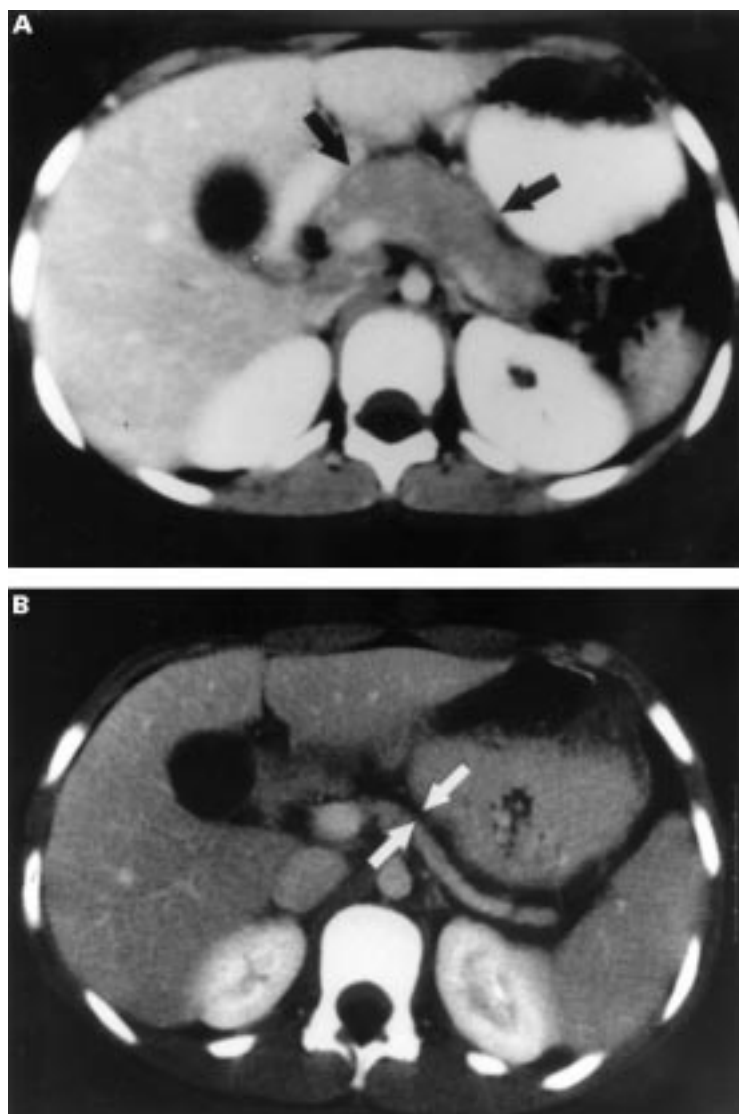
Abdominal CT scan of patient 1 at presentation (A) shows diffuse enlargement of the pancreas (black arrows). A follow up CT 18 months later (B) reveals pancreatic atrophy (space between white arrows).
